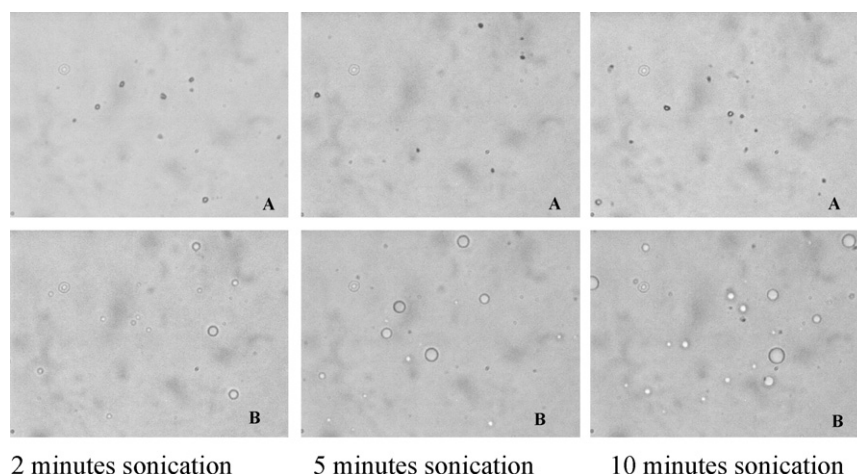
Morphology of formulations A and B after exposure to 2, 5 and 10 min ultrasound.
